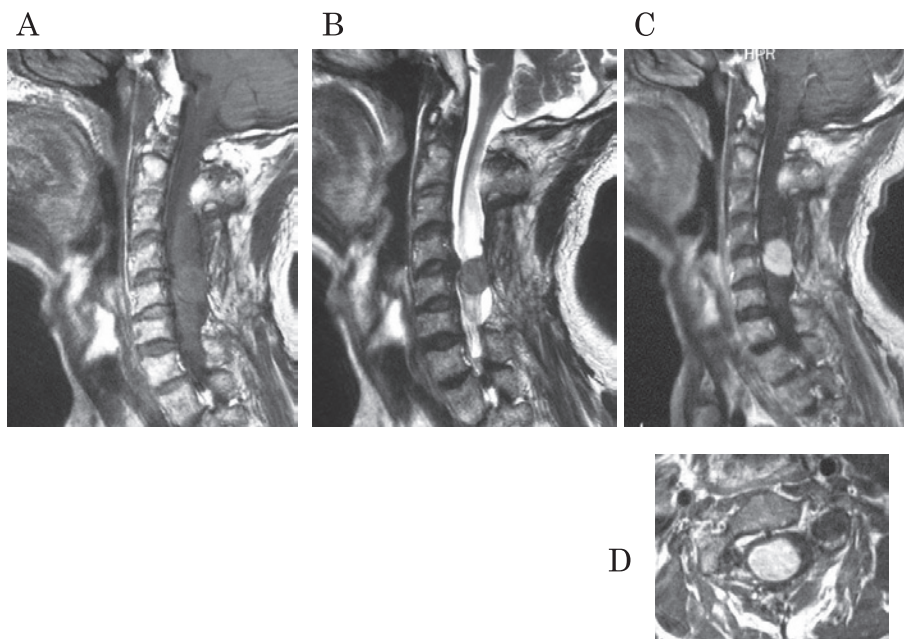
Magnetic resonance imaging at the time of the initial consultation with our hospital. Sagittal T1-weighted (A) and T2-weighted (B) of the cervical cord gave isointense and iso- to hyperintense signals due to an intradural tumor at the C4–5 level. Sagittal T1 gadolinium-enhanced (C) and axial (D) images showed homogenous enhancement.
